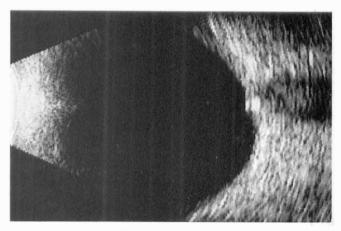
B-mode ultrasonography demonstrating high reflectivity characteristic of drusen.*
